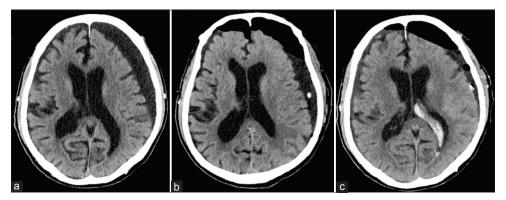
(a) Computed tomography scan showing a left CSDH, (b) Postoperative CT scan showing no obvious findings, (c) CT scan the day after the operation revealing a left intraventricular hemorrhage.
